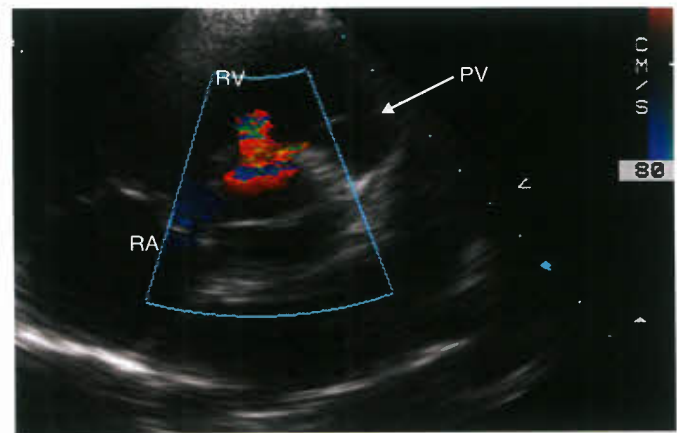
Parasternal short-axis imaging plane at the level of the aortic and pulmonic valves demonstrating color Doppler left-to-right flow across a supracristal VSD.
